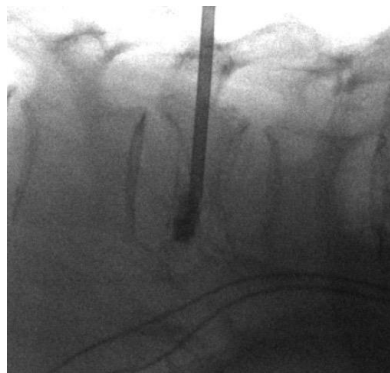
Radiographical lateral view using standard 2D X-ray mode by the same C-arm machine
